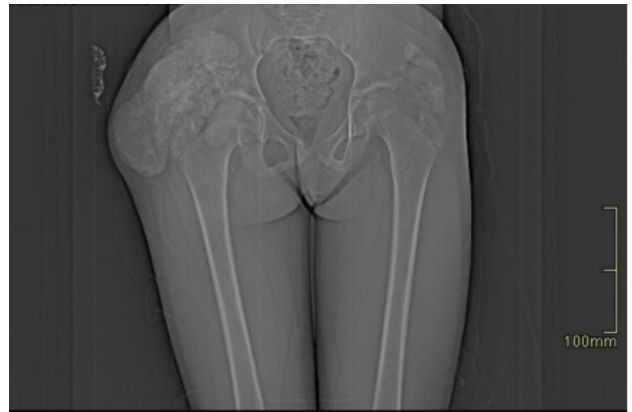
Preoperative CT scan shows juxta articular bilateral Trochanteric lobulated, cystic, calcified mass.
